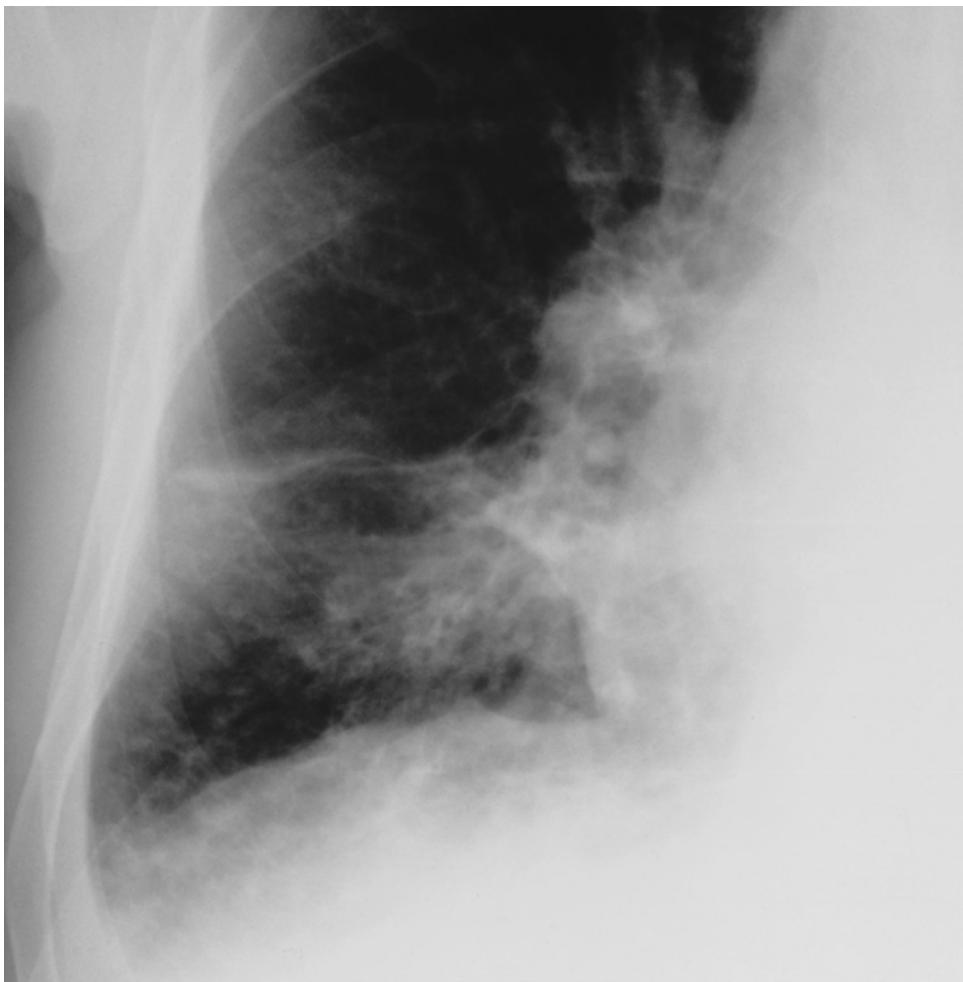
Extreme form of chronic bronchitis (detail). Massive interstitial shadowing in a 77-year-old man with a history of many years of cigarette smoking, radiograph obtained prior to placement of a cardiac catheter. Diffuse septal and peribronchial shadowing. The changes largely mask the normal vascular markings (analogous to ILO 3/2).
